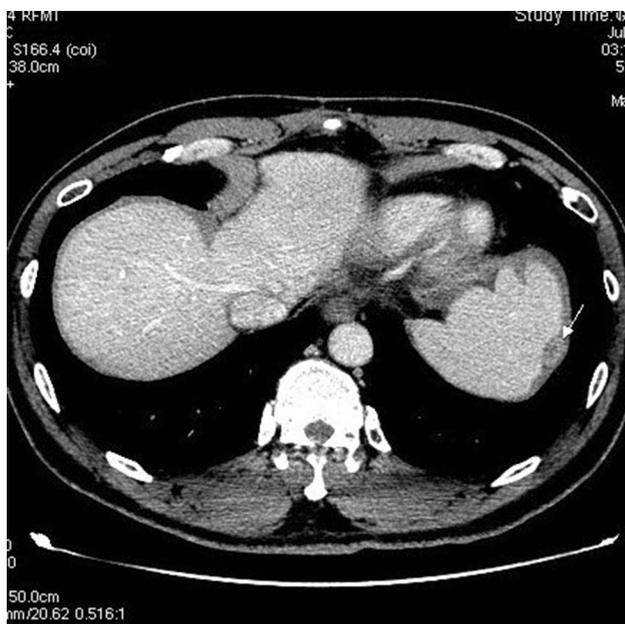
Computed tomography (CT) revealed a nodule (arrow) at left subdiaphragmatic region abutting on the spleen
